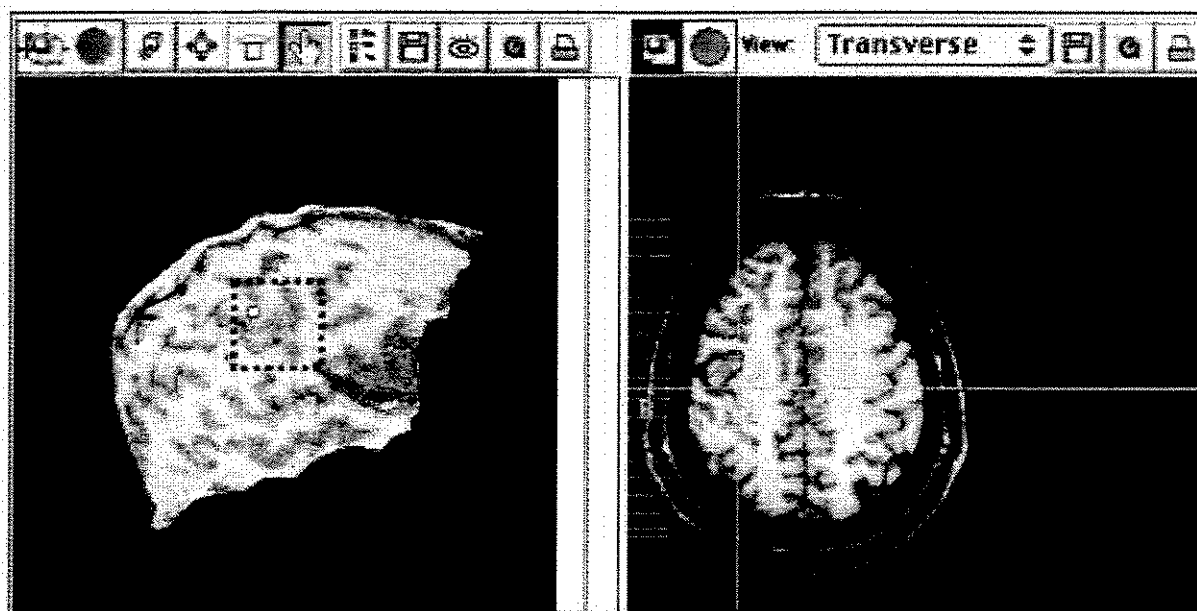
(A) Curvilinear reformatting at 16 mm of depth from the cortical surface shows a dysplastic lesion (within the box). The dot indicates the limit of the dysplastic lesion on the curvilinear reformatting image. (B) Axial T1-weighted image shows the dysplastic lesion in the right frontal region, and the limits of the lesion are contoured in black. Note that the cross-lines, which correspond to the exact position of the dot in (A), fall outside the limits of multiplanar reconstruction-defined lesion.
